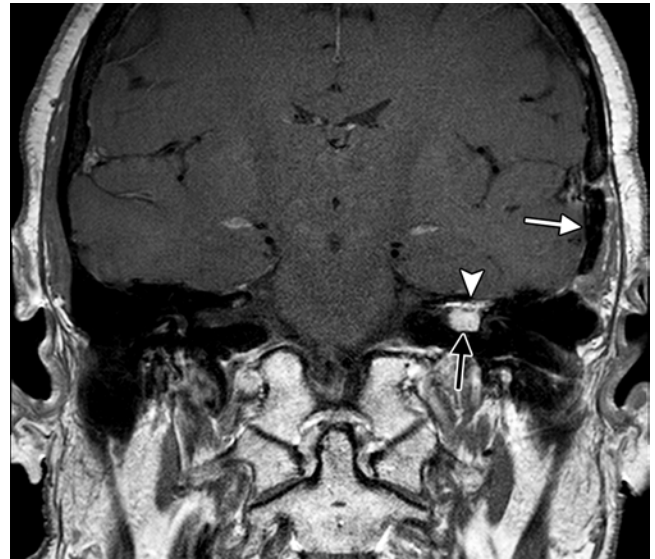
Middle cranial fossa approach. Coronal postcontrast T1-weighted MRI study showing the left temporal craniotomy site (white arrow) used to remove the roof of the internal auditory canal where a small amount of fat graft (arrowhead) has been applied. Tumor is present within the internal auditory canal (black arrow).
